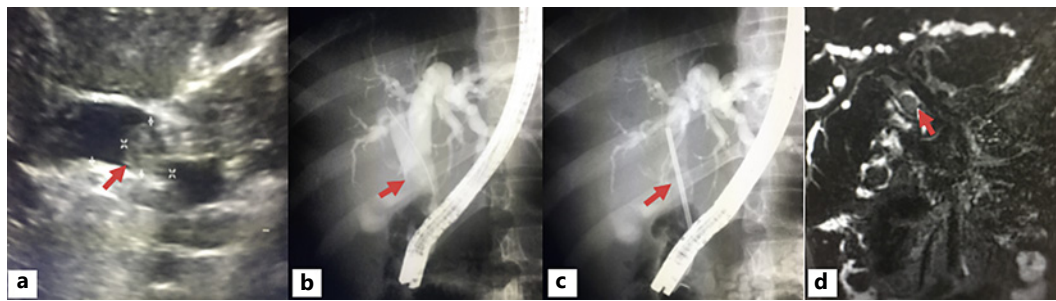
The bile duct ultrasound shows dilation in the common bile duct (a), endoscopic retrograde cholangiopancreatography reported a polyp that conditioned an increase in the volume of 50% of the intra- and extrahepatic bile duct (b), prosthesis was placed (c), and magnetic cholangioresonance was performed, in which dilation of the bile duct was reported (d).
